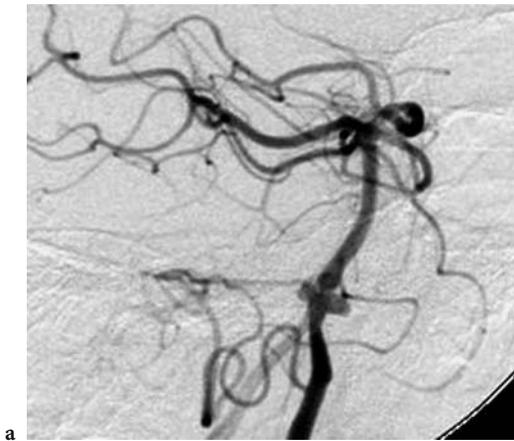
Before and after intended endovascular occlusion of a dysplastic PICA revealing at least four aneurysms. MRI: T2 images showed only a very small infarction in the PICA territory without causing clinical symptoms
